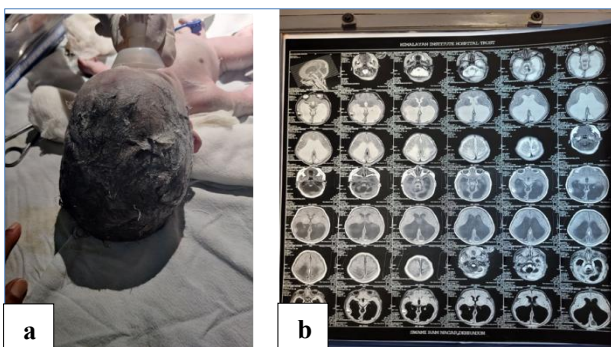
Intrapartum transvaginal cephalocentesis in case 1, (a) appearance of the fetal head immediately after decompression, showing marked reduction in size following drainage of approximately 400 ml of cerebrospinal fluid (CSF), and (b) postnatal neuroimaging (CT/MRI film images) demonstrating Dandy–Walker malformation with severe obstructive hydrocephalus.
